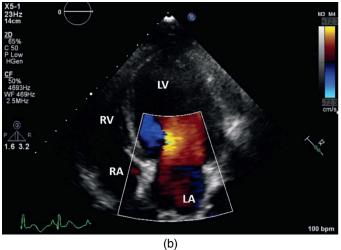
Apical 4 chamber views provide excellent color flow information as flow is more parallel to the Doppler cursor. (a) During early diastole in this patient there is aliased upward flow moving into the left ventricle. (b) During late diastole flow velocity is lower and non-aliased flow moves into the left ventricle.
